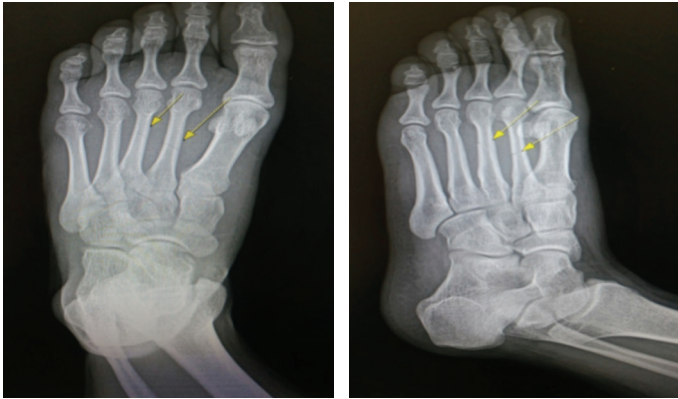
X-ray images taken on December 11, 2016.
